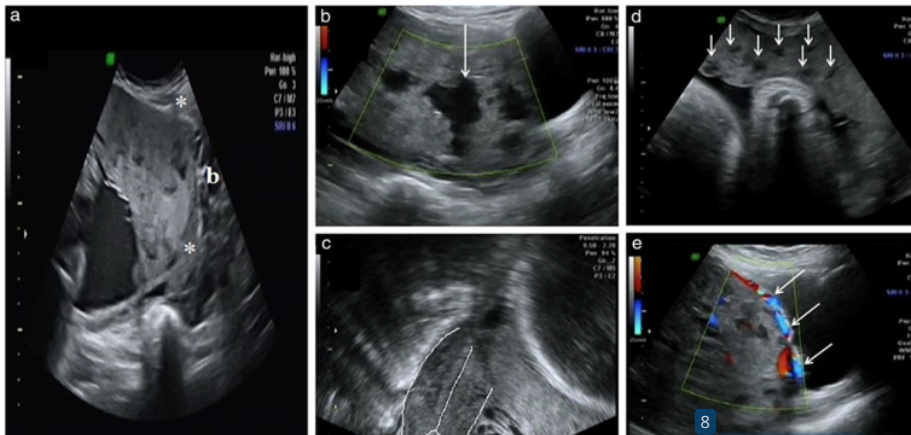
Sonography of morbidly adherent placenta parameter showing (A) Obliteration of the line of demarcation (*), (B) Lacunar size of ≥ 2 cm, (C) Placenta previa, (D) > 2 placental lacunae, (E) hypervascularity between the placenta and the bladder. Reproduced with permission from Tovbin et al.³⁹
